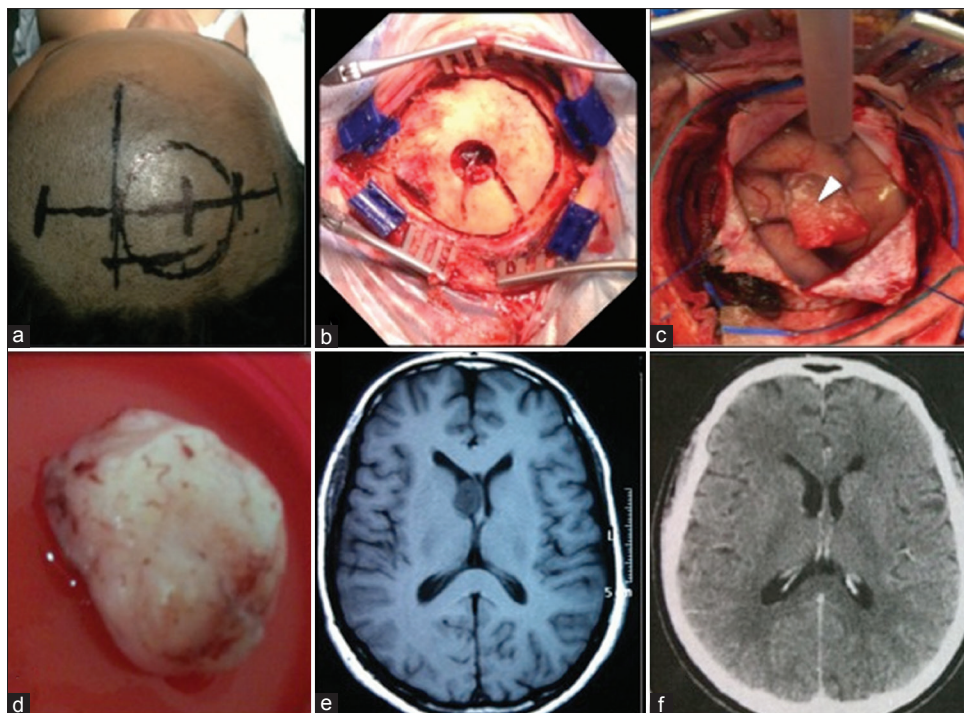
Case 3. (a) Routine surgical planning skin mark. (b) The craniotomy flap of 5 cm diameter. (c) Durotomy with exposure of the cortex and the hemostatic sponge sealing the endoscopic cortical access (arrowhead). Anterior positioning of the cerebral spatula fixed by the Layla brace for microsurgical exploration through the endoscopic path. (d) Subependymoma removed after conversion. (e) Axial T1-weighted magnetic resonance imaging obtained 2 months preoperative. (f) Axial computed tomography of the head obtained 3 months after the surgery
